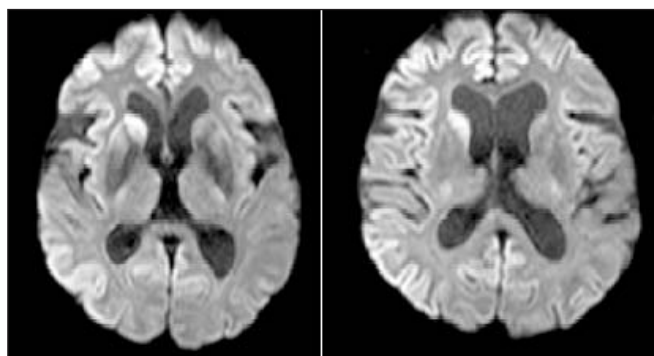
Patient B. brain MRI. Hyperintense signal on the right caudate nucleus and the right hemisphere cortex (DWI sequence).
